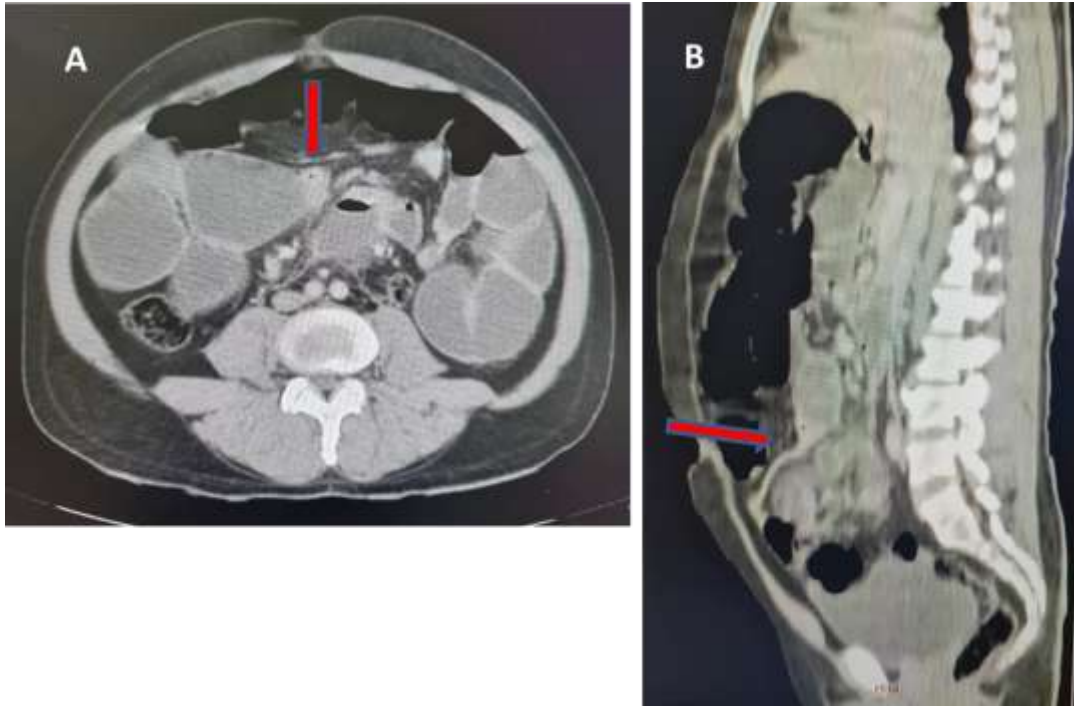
(A and B) Abdominal CT in axial (A) and sagittal (B) reconstruction after injection of contrast product showing the transition zone upstream of small intestine dilatation.
